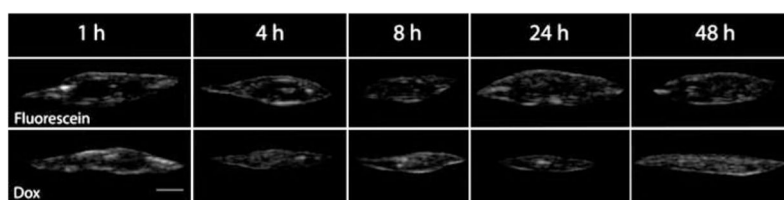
Representative ultrasound gray-scale images of implants formed subcutaneously; *scale bar* represents 2.5 mm
